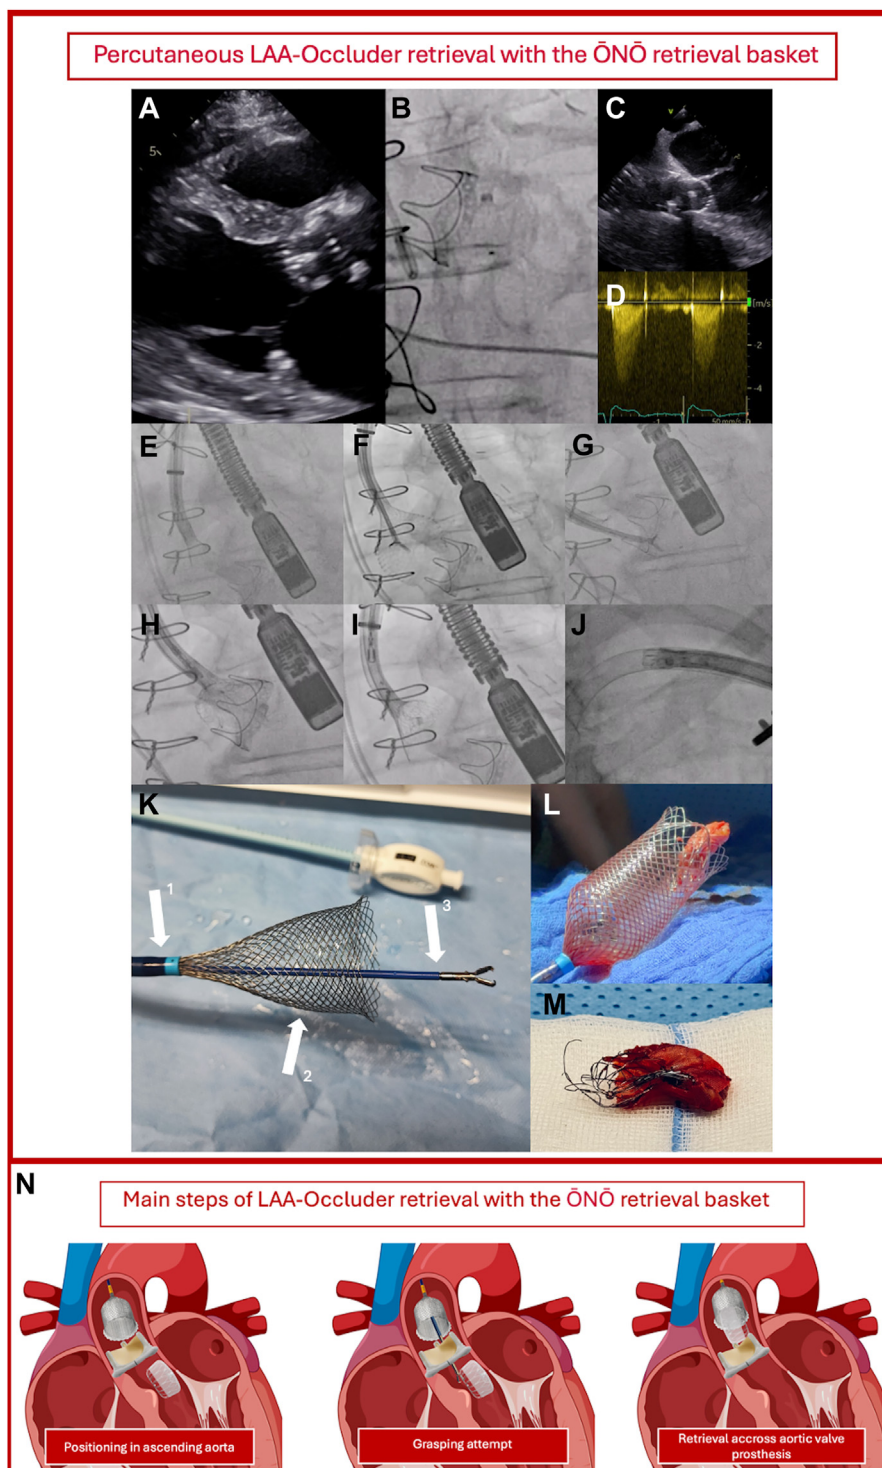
Percutaneous left atrial appendage occluder retrieval with the $\bar{O}\bar{N}\bar{O}$ retrieval basket. (A) Transthoracic echocardiography, (B) intra-procedural angiography, and (C) transesophageal echocardiography, showing embolisation of the Watchman Fix Device into the left ventricular outflow tract in front of the biological aortic valve prosthesis. (D) Severely increased transvalvular gradients in a patient with reduced left ventricular ejection fraction. (E) Delivery of the $\bar{O}\bar{N}\bar{O}$ retrieval basket and the Raptor grasping device through the Destino twist deflectable steerable 14-F guiding sheath (arrow no. 1 in K), all inside a 20-F Dry Seal Flex Introducer sheath. (F) Positioning of the $\bar{O}\bar{N}\bar{O}$ retrieval basket in the ascending aorta. (G) Grasping attempt of the dislocated Watchman device. (H, I) Retrieval of the grasped Watchman device traversing the aortic valve prosthesis into the $\bar{O}\bar{N}\bar{O}$ retrieval basket. (J) Retraction of the whole system (Watchman device, grasping device, and $\bar{O}\bar{N}\bar{O}$ basket) into the 13.8-F sheath. (K) Mounted system comprising the $\bar{O}\bar{N}\bar{O}$ retrieval basket (arrow no. 2) and the Raptor grasping device (arrow no. 3) before use. (L) Retrieval of the Watchman Fix device inside the $\bar{O}\bar{N}\bar{O}$ retrieval basket. (M) Retrieved Watchman Fix device. (N) Main steps of the left atrial appendage occluder retrieval.
